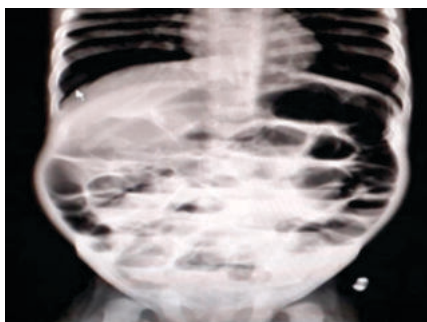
X-ray Showing Multiple Air Fluid Levels, Necrotising Enterocolitis
